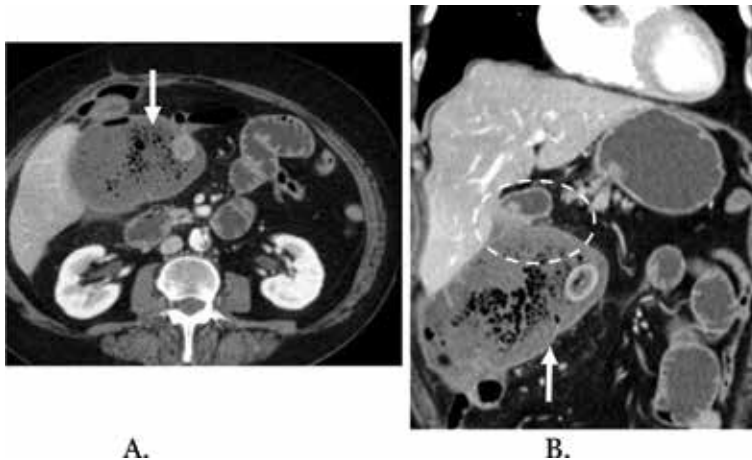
(A and B) A patient presented with severe constipation and no bowel movements for over 1 week. Axial and coronal images from a contrast-enhanced CT show large feces that distend the cecum and ascending colon (arrow) due to a stricture at the hepatic flexure (circle). The stricture is due to post-surgical fibrosis that developed between the colon and the site of a prior cholecystectomy (circle).
